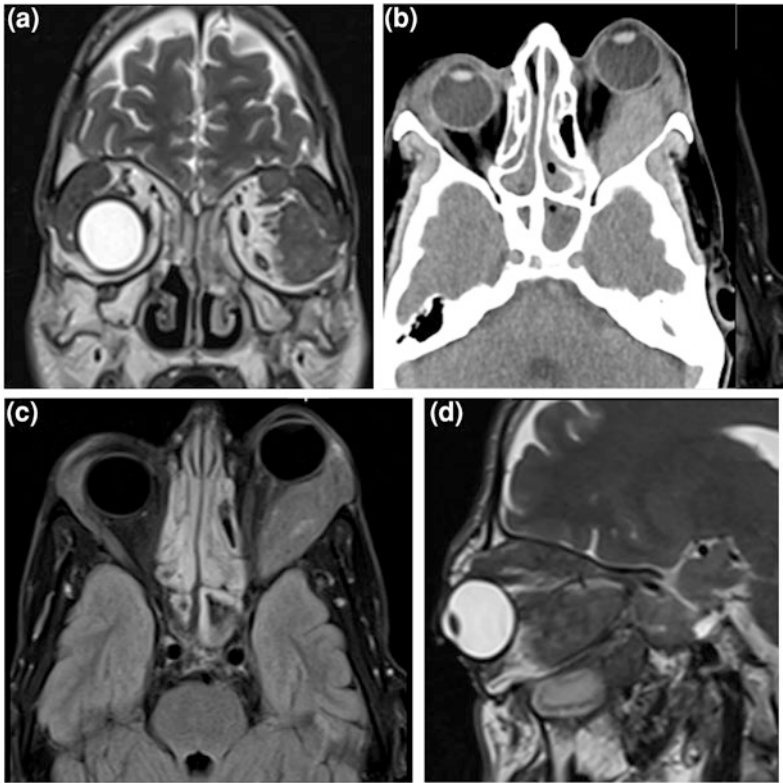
MR and CT images for a case of lymphoma. a, b Coronal and sagittal T2 WI and c FLAIR WI with fat suppression showing bilateral enlargement of both lacrimal glands larger on the left side with left intraorbital extraconal masses of isointense T2 signal. These lesions appear hyperdense on the unenhanced CT scan (d)
